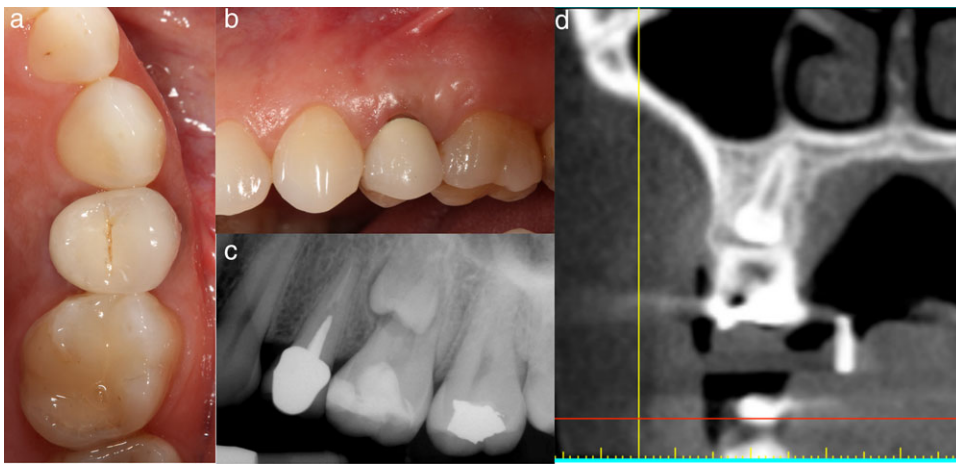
Preoperative clinical and radiographic examination. Occlusal (1a) and buccal (1b) views. 1c Periapical radiograph of tooth #12 with non-retainable porcelain-fused-to-metal crown and impacted tooth #13 (under tooth #14). 1d Cone-beam computed tomography scan showing fully impacted tooth #13 under the furcation of tooth #14.
